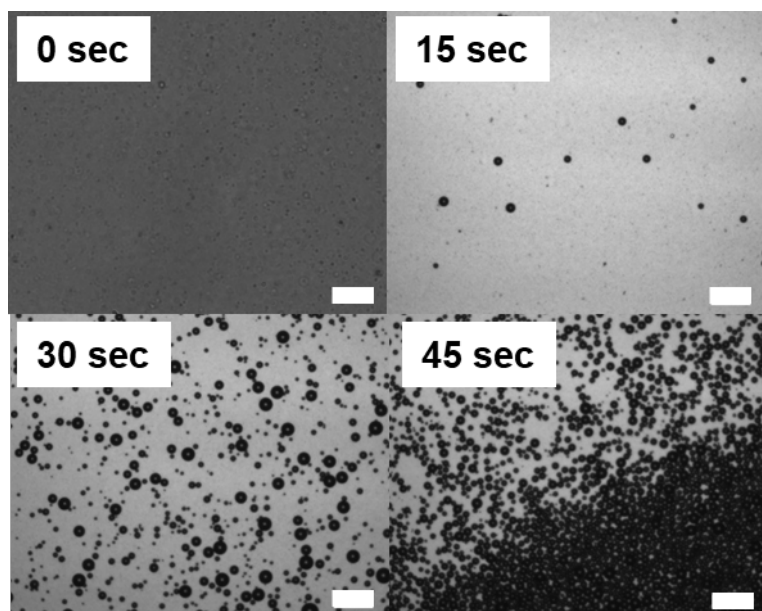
Optical images of PDA nanodroplets before and after 15, 30 and 45 seconds of ultrasound exposure (continuous wave, 1.8 MHz, 265 kPa). Scale bars are 200 μm .
